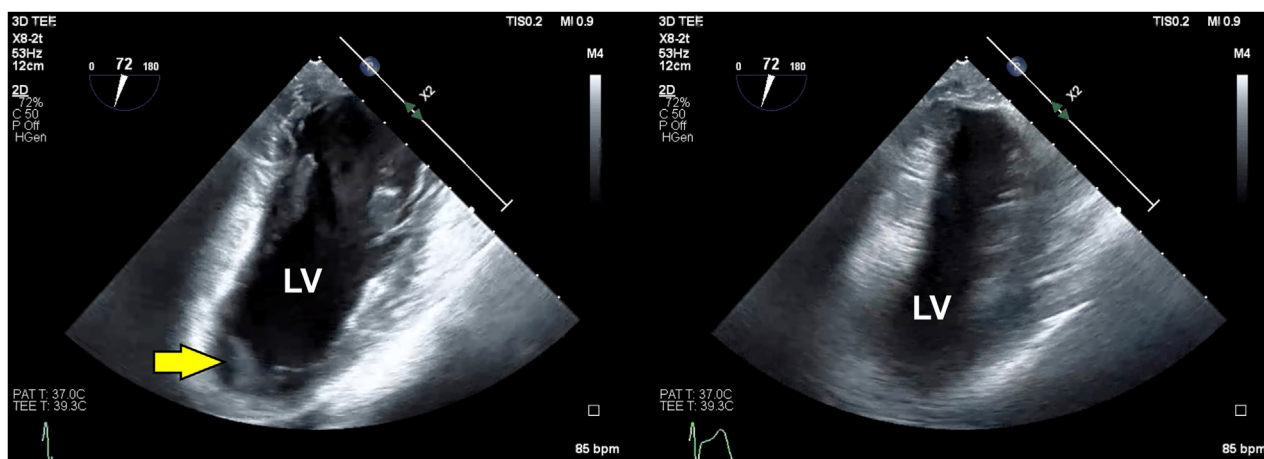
Two-dimensional transesophageal echocardiography (day 16, before CPB), midesophageal, left ventricular-focused modified two-chamber (72°) diastolic (left) and systolic (right) displays, demonstrates an intraventricular thrombus attached to the left ventricular apical wall (arrow). LV, Left ventricle.
